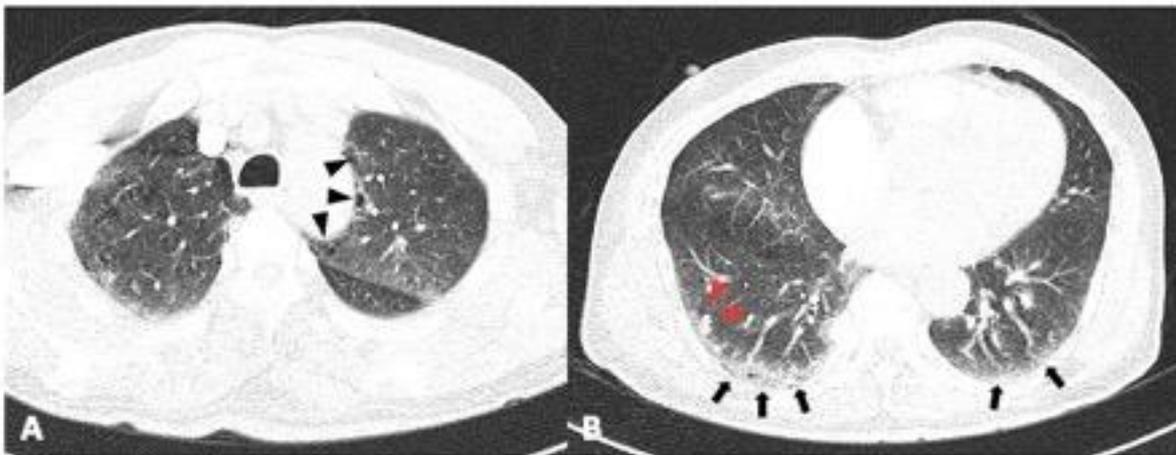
Serial axial computed tomography (CT) of the upper and lower thorax images in the lung window showing: (A) - Several pulmonary bullae (black arrowheads) at the medial apicoposterior segment of the left upper lobe. (B) - Peripherally distributed ground-glass densities at both posterobasal segments (black arrows), typically seen in COVID-19 pneumonia. Also, note few nodular densities (red arrowheads) at the right laterobasal segment.
